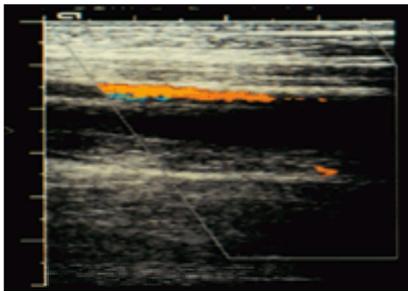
Thrombophlebitis in a 15-year-old girl with Behçet's disease. Colour Doppler shows a thrombosis of the superficial femoral vein.
